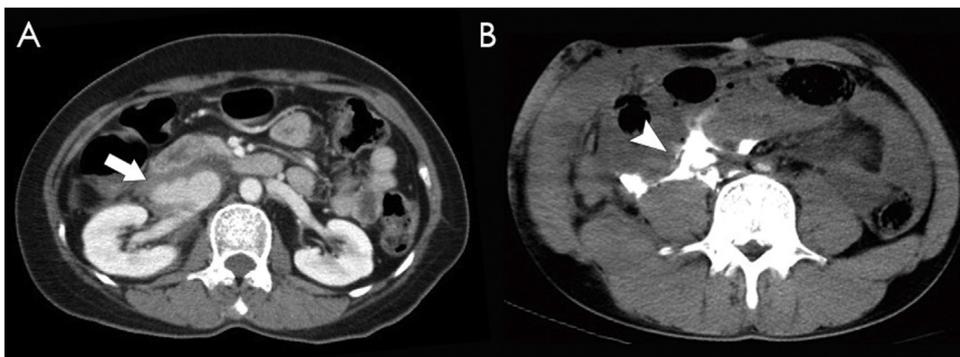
Axial view of a computed tomography scan of vena caval trauma. (A) An infrarenal vena caval injury with pseudoaneurysm formation (arrow). (B) A vena caval injury with contrast extravasation (arrowhead).
